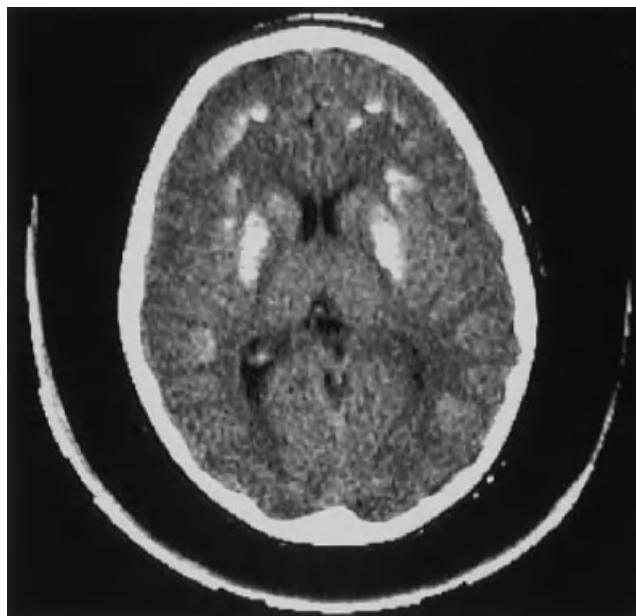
Computed tomography image of basal ganglion and frontal lobe calcification in pseudohypoparathyroidism type Ia.
